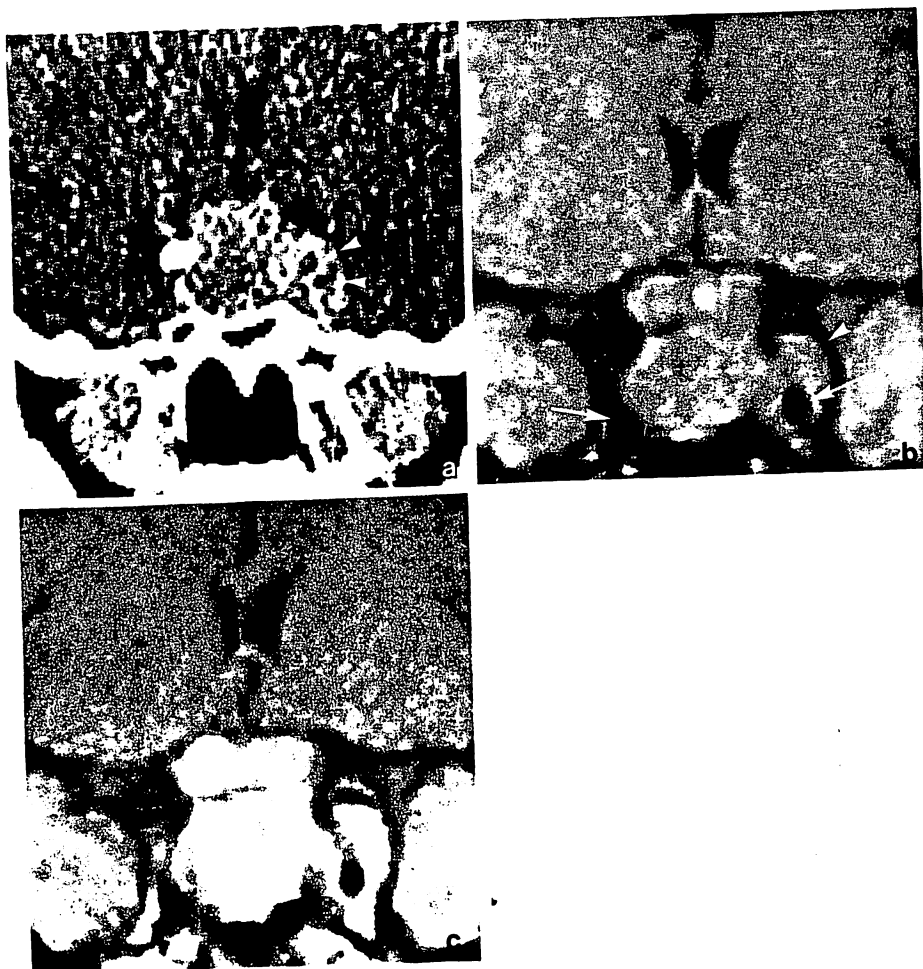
A 24-year-old female with human growth hormone producing pituitary adenoma (case 11). a Enhanced CT demonstrates the bulging of the left cavernous sinus (arrowheads). However, it is difficult to differentiate internal carotid arteries from the tumor. b T1-weighted SE image without Gd-DTPA. Internal carotid arteries are clearly demonstrated as low intensity area (arrows). The left internal carotid artery is markedly displaced laterally and engulfed by the tumor. The tumor extends to the left lateral wall of the cavernous sinus (arrowhead). c T1-weighted SE image with Gd-DTPA. The tumor is enhanced with Gd-DTPA
